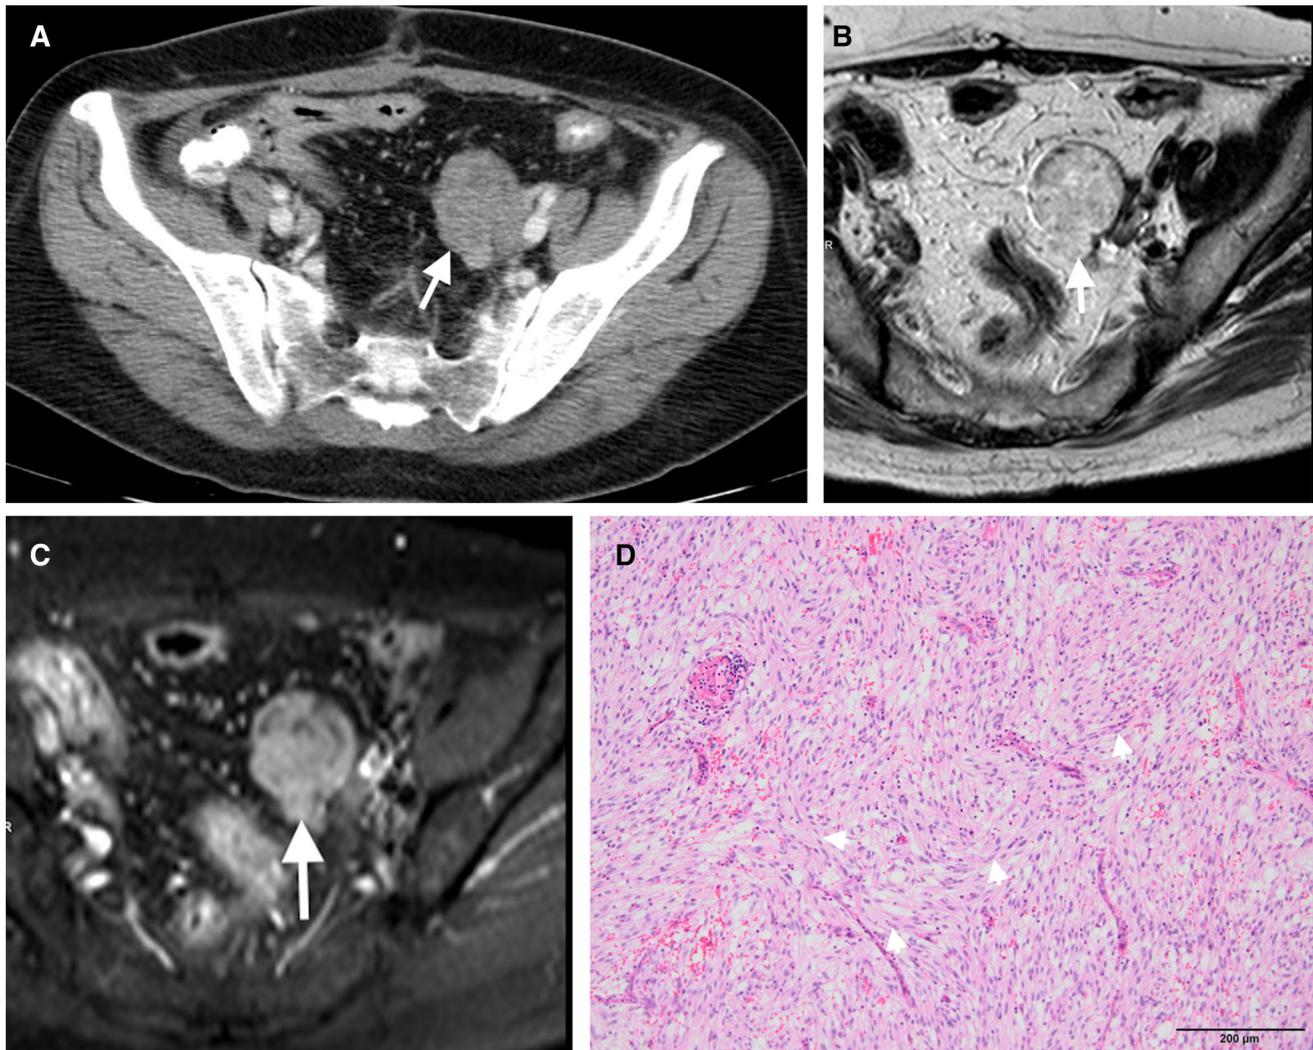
Sixty-two-year-old woman with a history of ileal GIST treated with surgery and chemotherapy 4 years ago. The patient was under clinical remission since then. A Axial post-contrast CT image demonstrated a newly appeared left adnexal mass (arrow). B Axial T2-weighted MR image showed hyperintense solid mass (arrow) with well-defined
